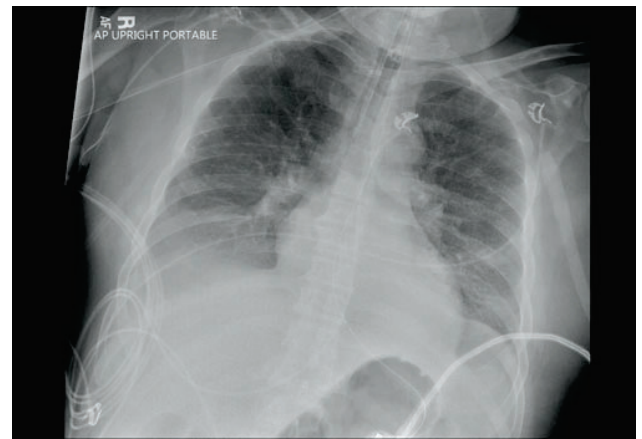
Chest radiograph on day 3 of mechanical ventilation demonstrating near resolution of diffuse bilateral infiltrates.
